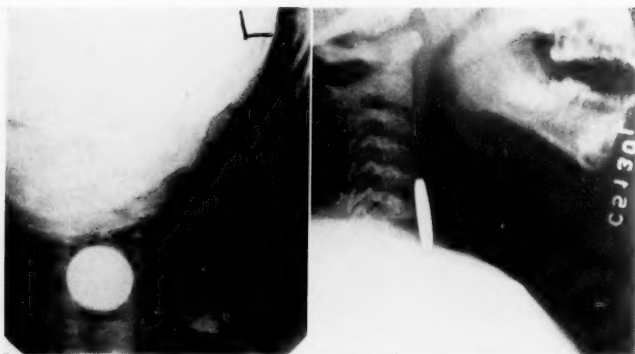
X-ray films showing typical position of a coin arrested in the upper esophagus. A P and lateral views show the plane to be opposite to that involved in laryngeal foreign bodies.
